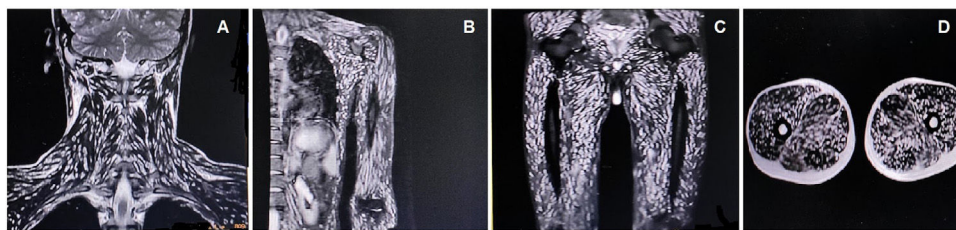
Magnetic resonance imaging of the neck and limb muscles shows the presence of generalized deposits of cysticercus larvae (A–D).
